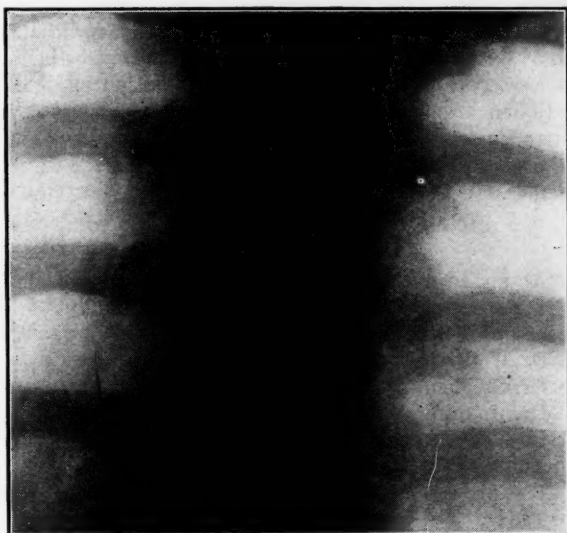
Radiograph of the chest revealing the pin
